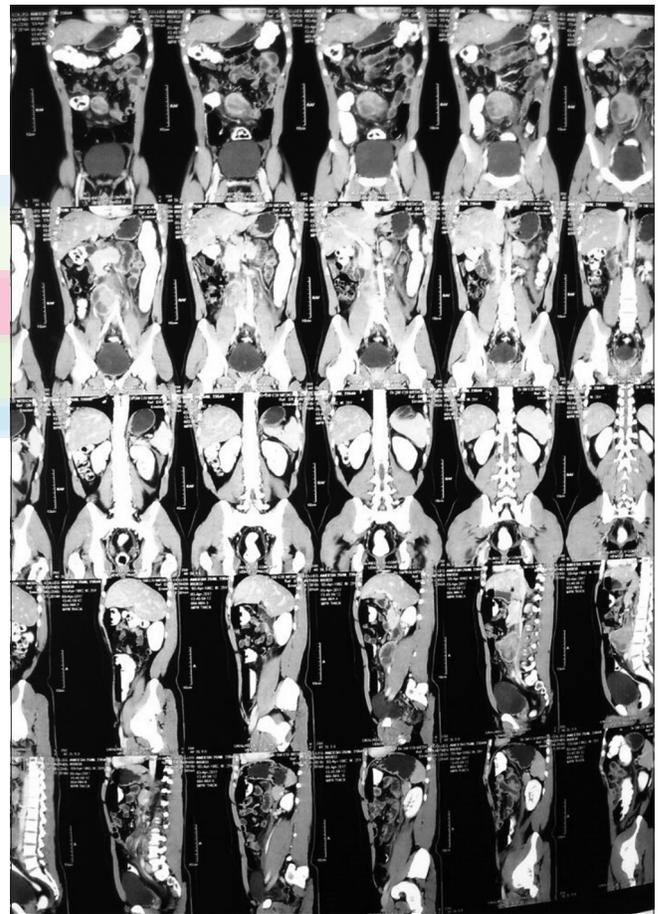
Computed tomography abdomen-sagittal and coronal view
